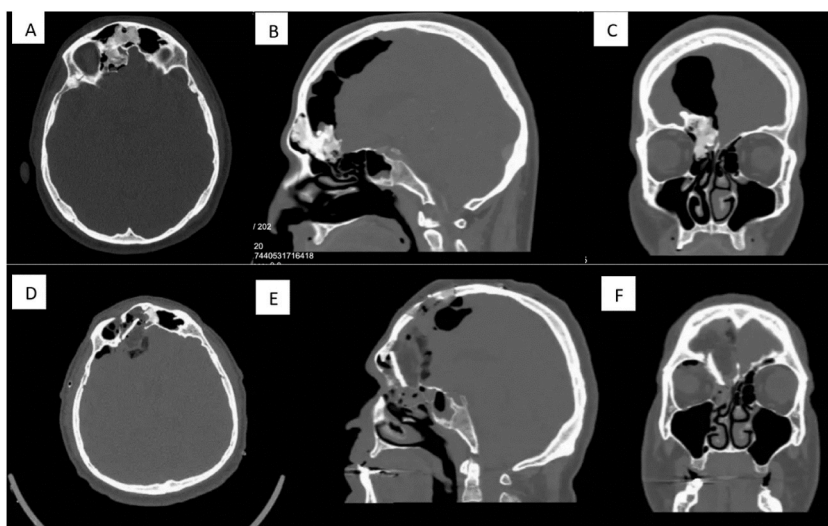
(A) Axial; (B) Sagittal and (C) Coronal CT views of the brain and paranasal sinuses preoperatively demonstrating a fibro-osseous lesion in the right frontal and ethmoid sinuses extending towards frontobasal lobe accompanying significant pneumocephalus. (D) Axial; (E) Sagittal and (F) Coronal CT views of the brain and paranasal sinuses postoperatively displaying tumor removal and anterior skull-base reconstruction.
